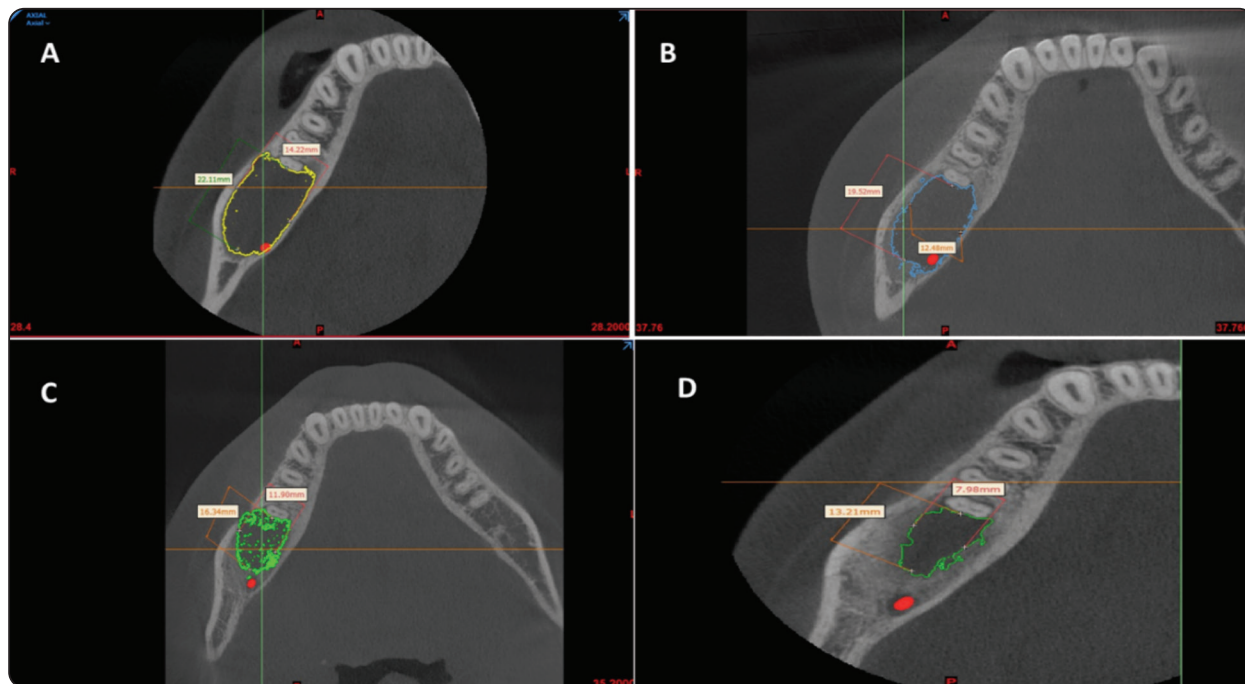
CBCT Axial cuts representing marked decrease in cystic diameter during follow up periods: A) preoperative. B) 3months postoperative. C) 6 month postoperative. D) 9 month postoperative.
